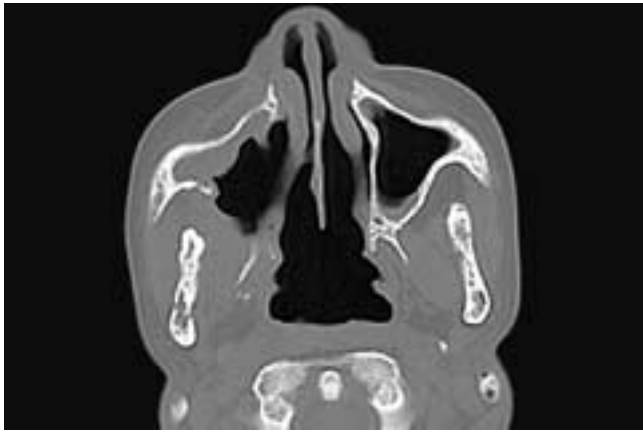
Axial CT scan viewed at wide window settings shows interruption of the cortices of both mandibular rami. There is loss of some of the medullary septations and there are areas of sclerosis. There is a non-displaced fracture of the anterior left ramus. Similar changes are also present in the zygomas. This patient had radiation osteitis after RT treatment and surgery for a right medial wall maxillary sinus carcinoma. The surgical defect is seen as is the partial resection of the right pterygoid plates.
